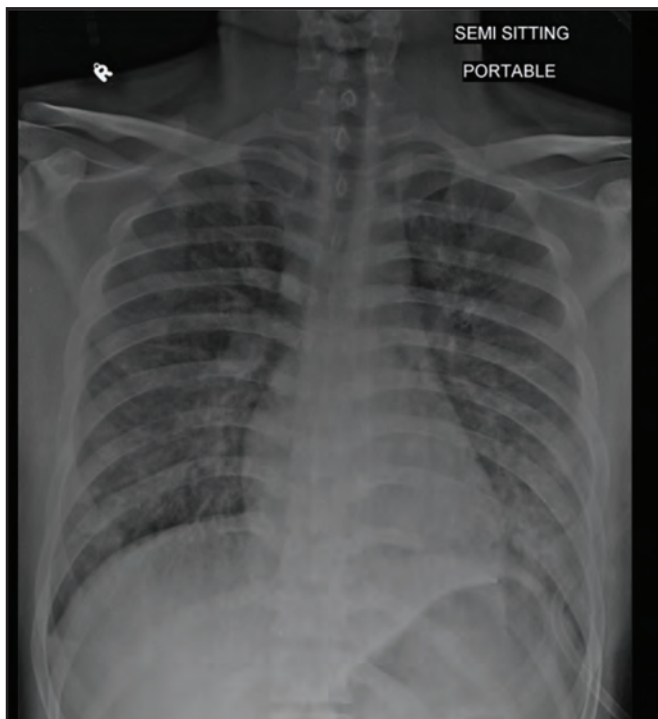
Chest radiograph showed pulmonary oedema and upper lobe diversion.
